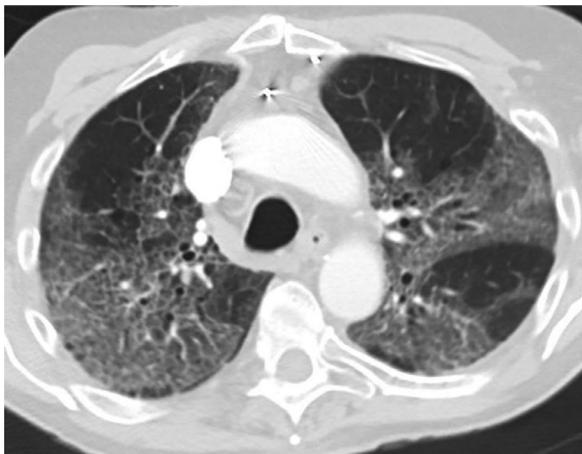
Axial CT demonstrates a pattern of disease characterized by ground-glass opacity and interlobular septal thickening, giving a “crazy paving” appearance in this patient with a background of mild emphysema.
